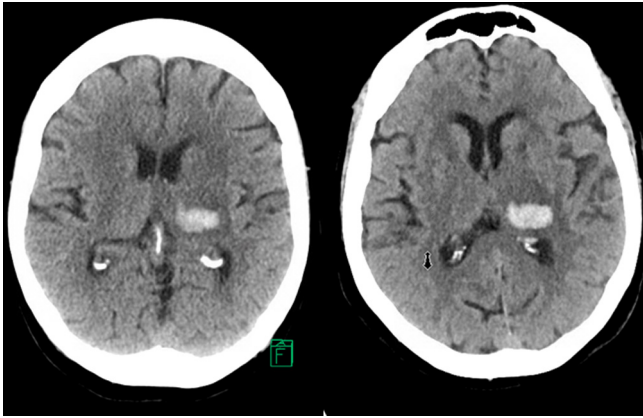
Axial non-contrast CT scan of the head showing an acute hemorrhage in the left thalamus measuring 2×1 cm in axial section with no significant mass effect or midline shift (left). Repeat CT scan done after 24 hours demonstrating stable hemorrhage (right).
